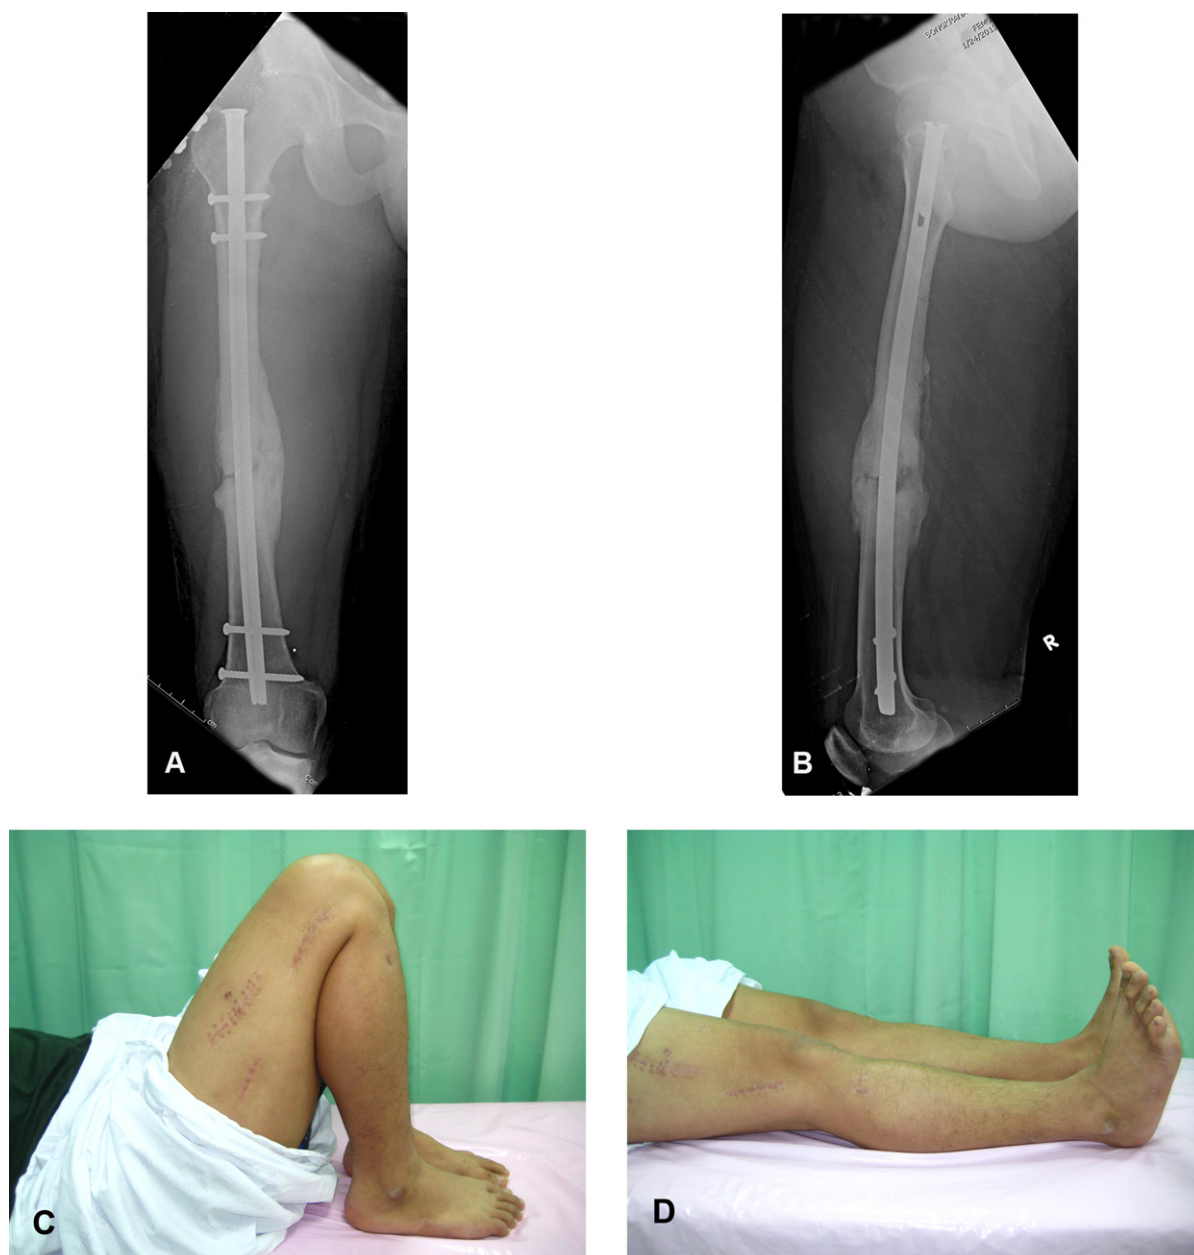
Radiographs showing the complete healing of the femoral shaft fracture (A and B). The patient had a full range of motion of right hip, knee and ankle (C and D).
